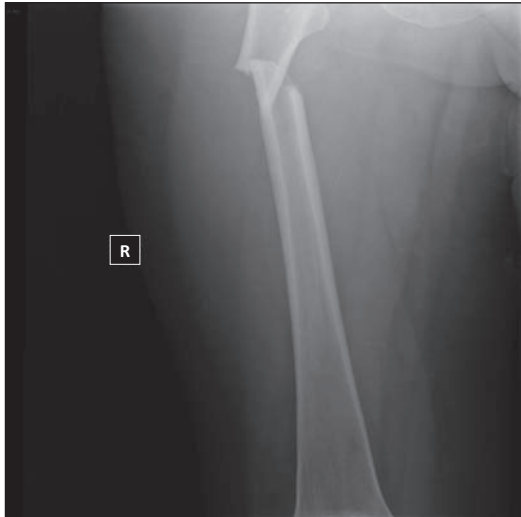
Plain radiograph shows transverse oblique fracture in the proximal shaft of right femur.
